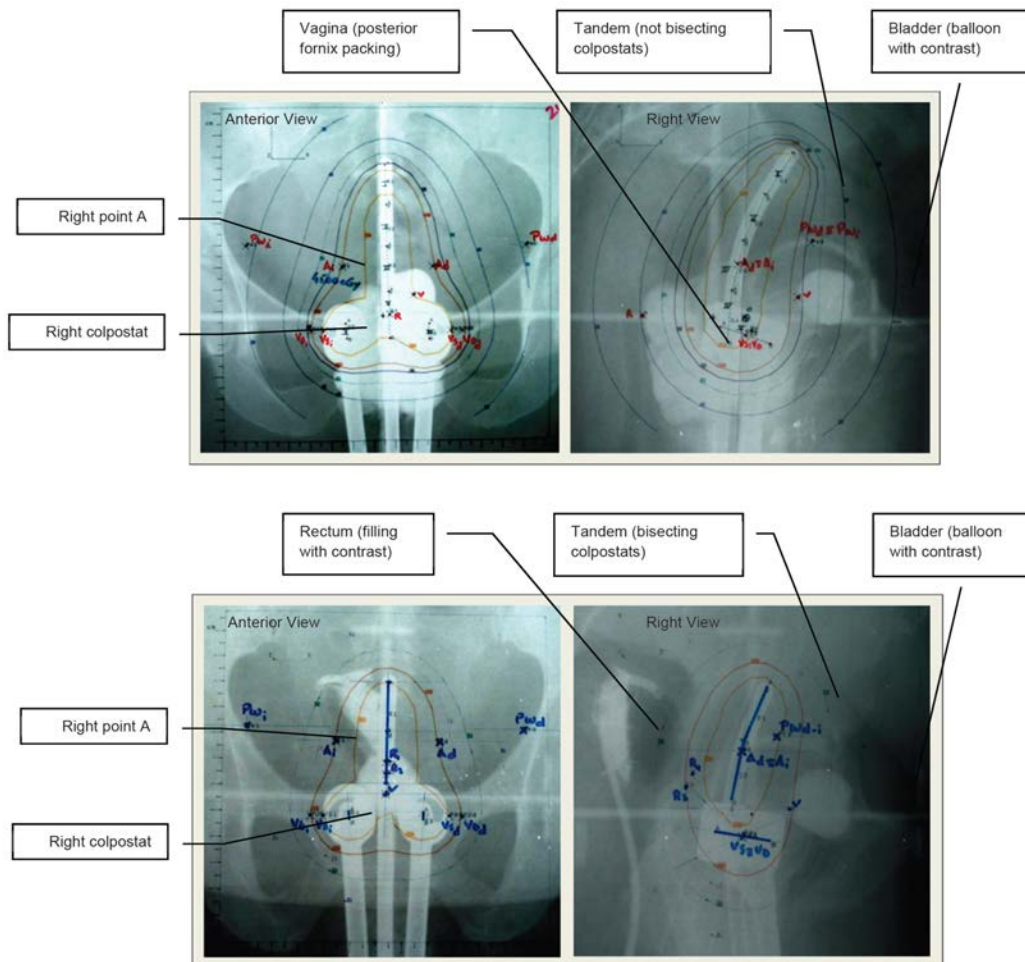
Anterior and lateral radiographs following insertion of Fletcher applicators for LDR manual afterloading BT technique. (Images courtesy of S. Binia.)
